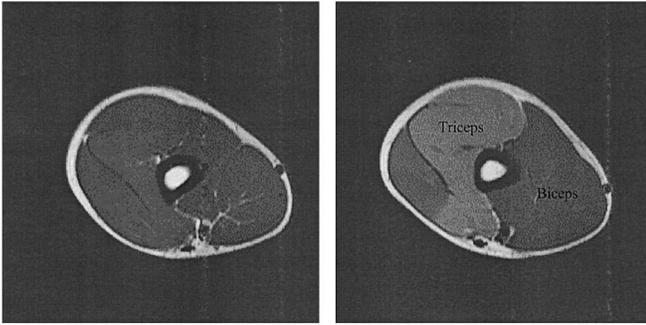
Axial MR images (TE = 50 ms, TR = 1.5 s, 16 cm field-of-view, 1 cm thick slice) across upper left arm of a healthy subject before (A) and after (B) performing elbow extension exercise.
